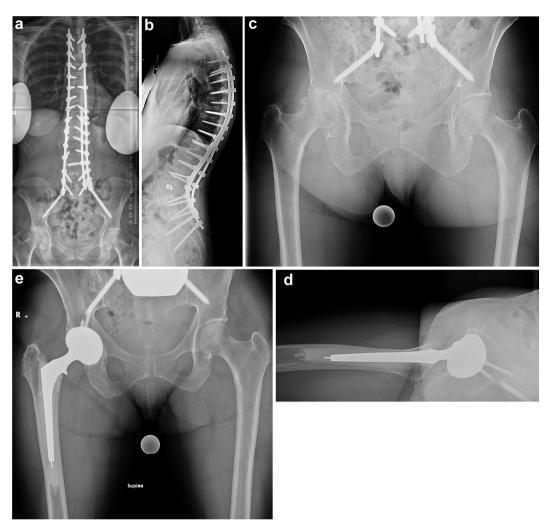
Preoperative AP (a) and lateral (b) scoliosis radiographs of a 67-y-old female after a 14-level fusion from T4 to the sacrum with end-stage right hip osteoarthritis evident on the AP pelvis radiograph (c). She underwent hybrid THA (d and e) with a DM construct and did well at 3 y of clinical follow-up without dislocation.
